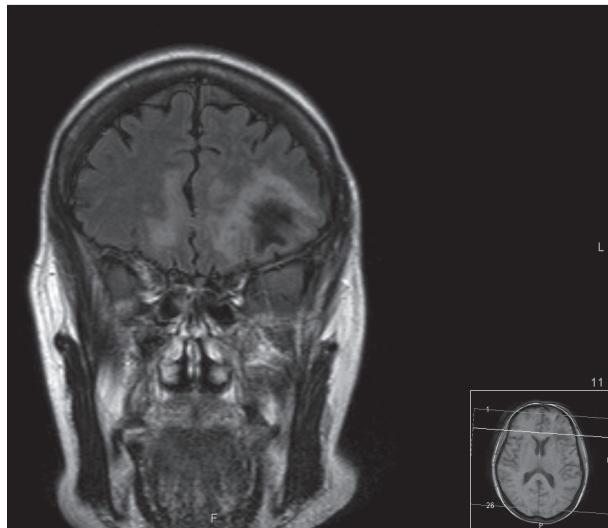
T2 FLAIR coronal MRI, showing typical appearances for PML
